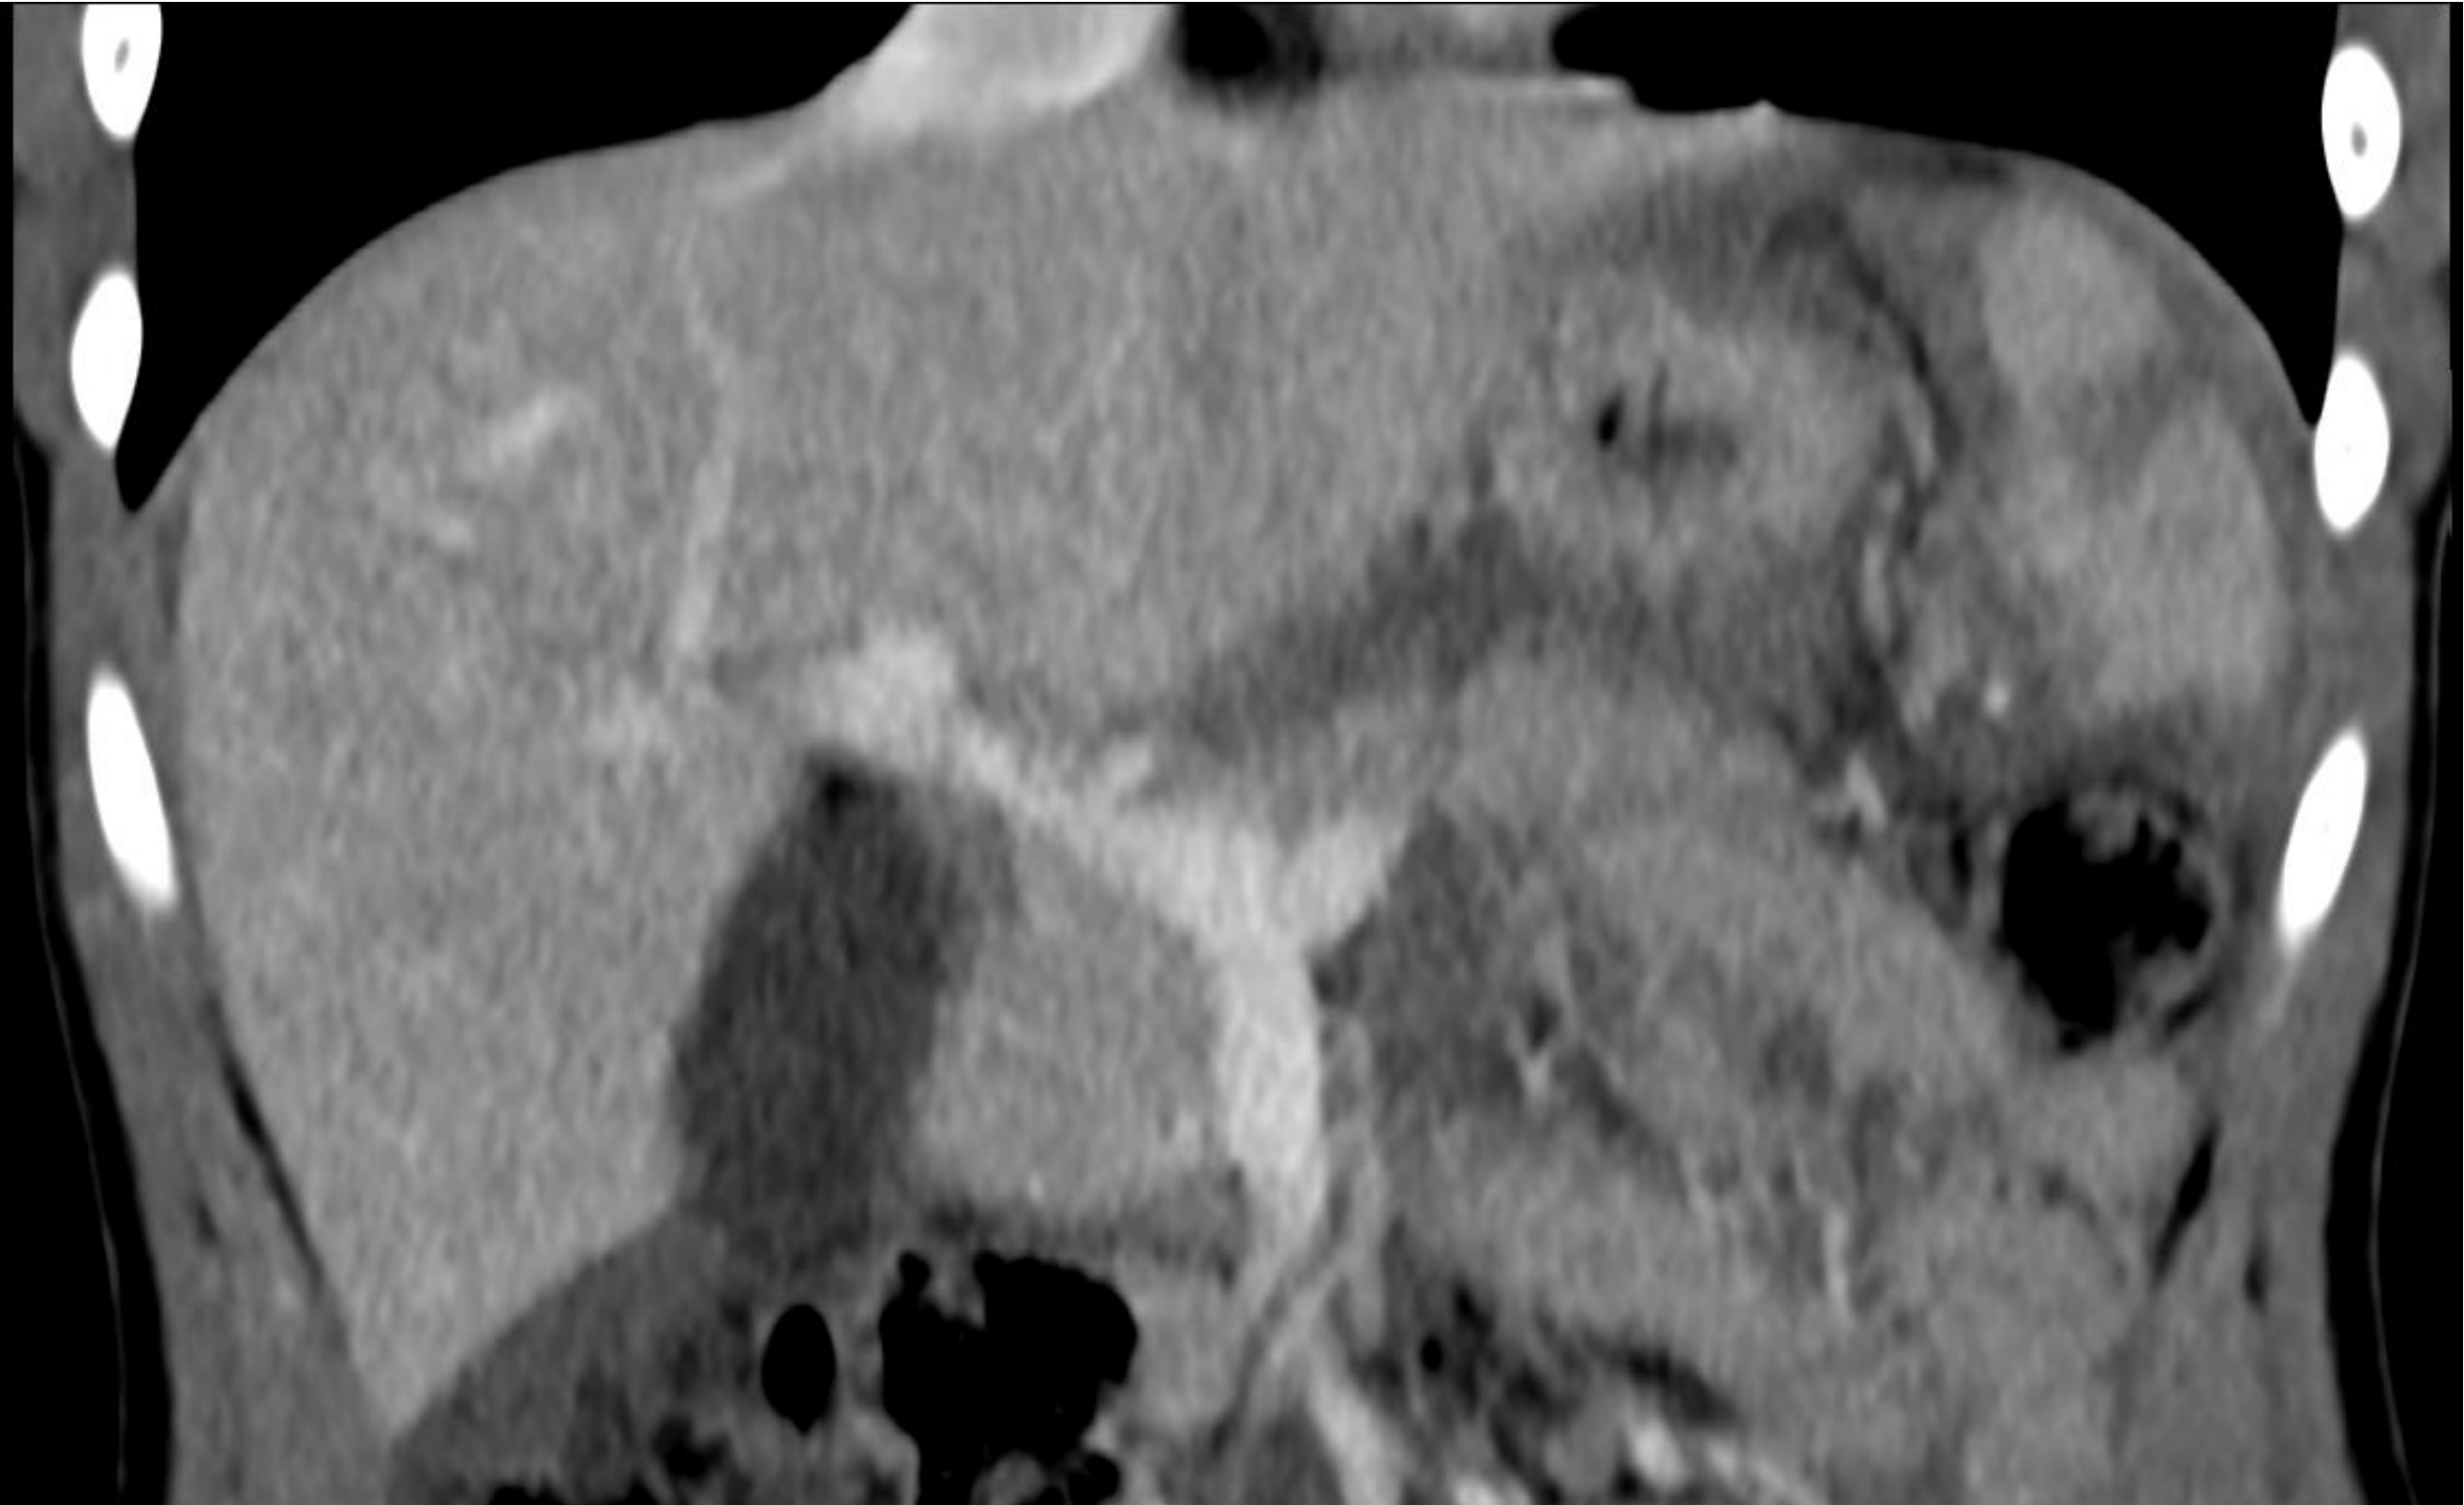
CT: Deep hilar splenic transection with hemoperitoneum, no active extravasation – coronal view.
